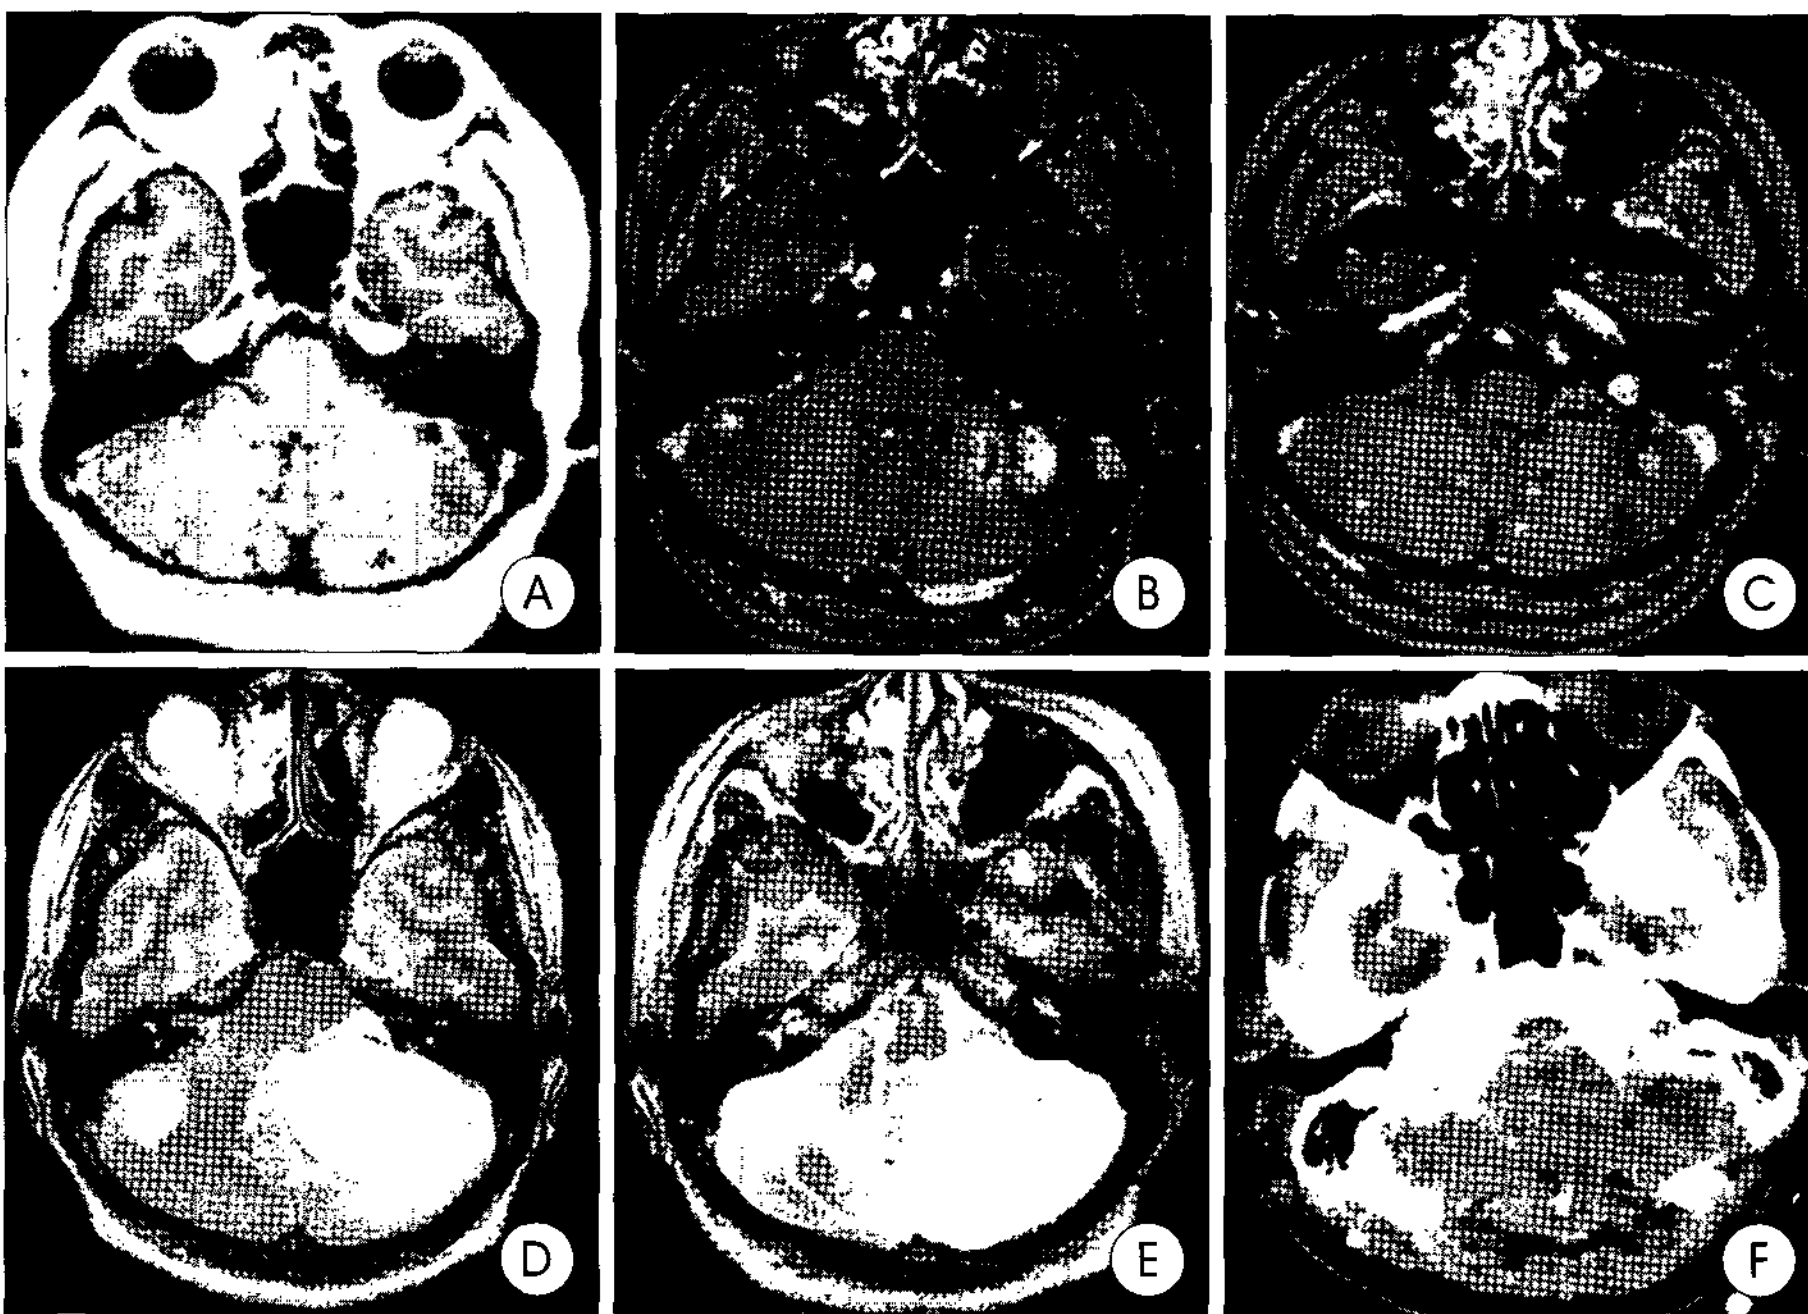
Case 6 : Axial gadolinium enhanced T1 and T2 weighted magnetic resonance(MR) images and computed tomography(CT). A : MR images on the first radiosurgery showing multiple tumors in the cerebellum. B : MR images six years after the first radiosurgery showing a large cystic lesions in left cerebellum, which needed surgical resection later. C and D : MR images on the second radiosurgery showing the resolution of previously treated tumors but also newly developed tumors. E and F : MR images revealing severe cerebellar swelling, so decompressive craniectomy is performed eight months after the second radiosurgery.
